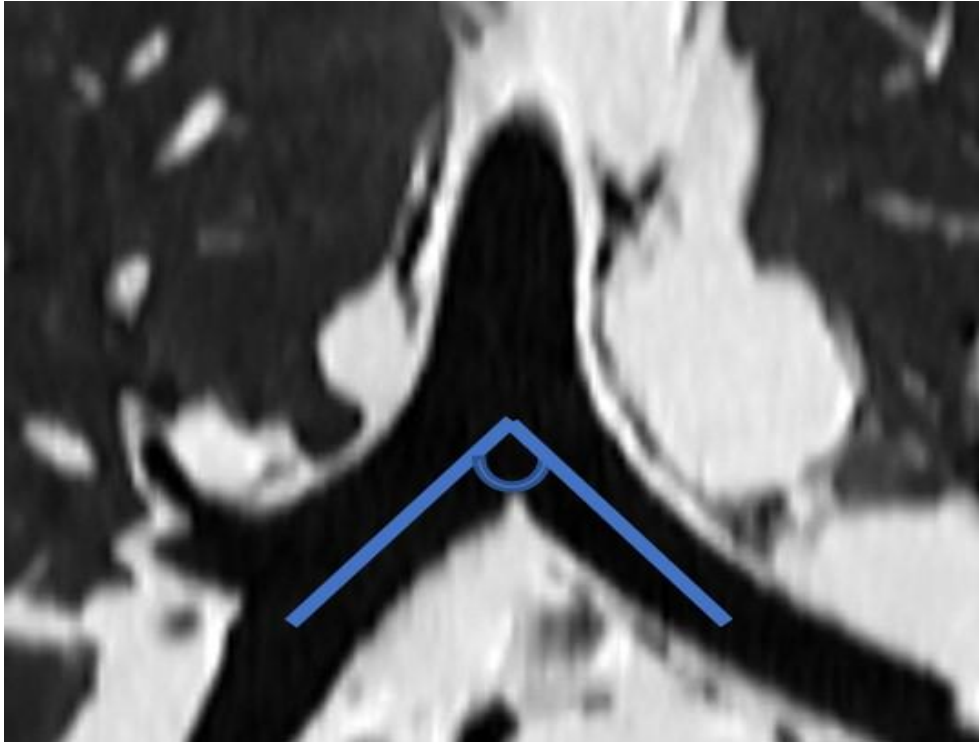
Interbronchial angle (IBA): The angle formed between the longitudinal axes of the right and left main bronchi on a coronal reformatted CT image
